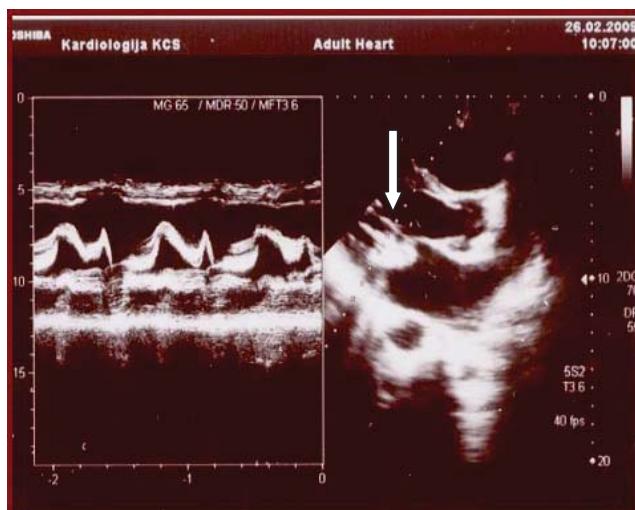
M and 2-D echocardiogram, parasternal long axis view presenting the huge vegetation (arrow) attached to anterior mitral leaflet (during medical therapy)
